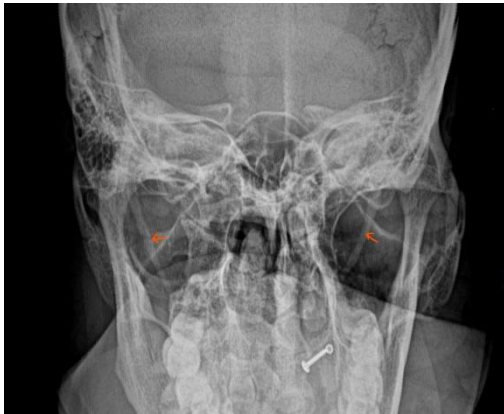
X-ray Towne’s view showing elongated styloid process.
